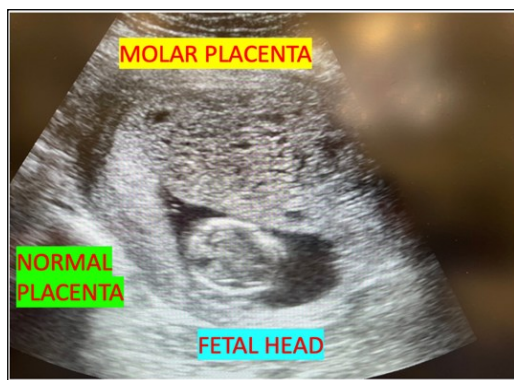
Transabdominal ultrasound at 15 weeks gestation demonstrating the viable fetus (F), the adjacent multicystic ‘molar’ placenta (MP), and the separate normal placenta (NP). Bilateral theca lutein cysts are also noted (not shown)."
